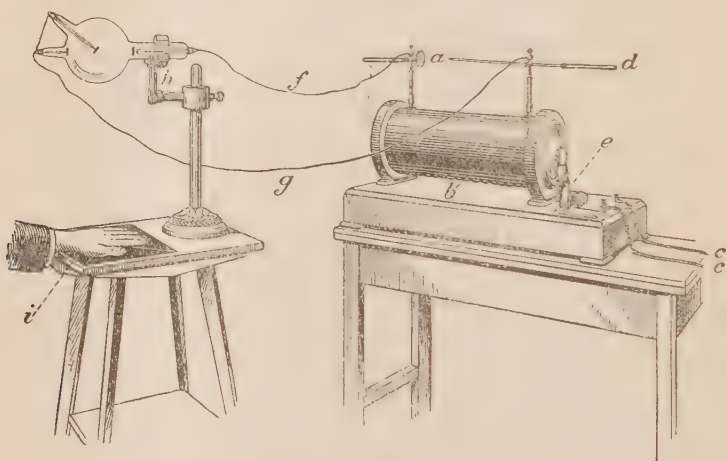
Apparatus for making an X-ray photograph, or for exposing a part of the skin to the action of the rays. *a*, Spark gap; *b*, coil; *c*, wires bringing current from the source of supply; *d*, movable rod for increasing width of spark gap; *e*, handle for closing primary circuit and starting the apparatus; *f*, *g*, wires connecting ends of secondary circuit through the vacuum tube; *h*, support carrying the vacuum tube; *i*, photographic plate in black paper envelope placed under the part to be photographed.
